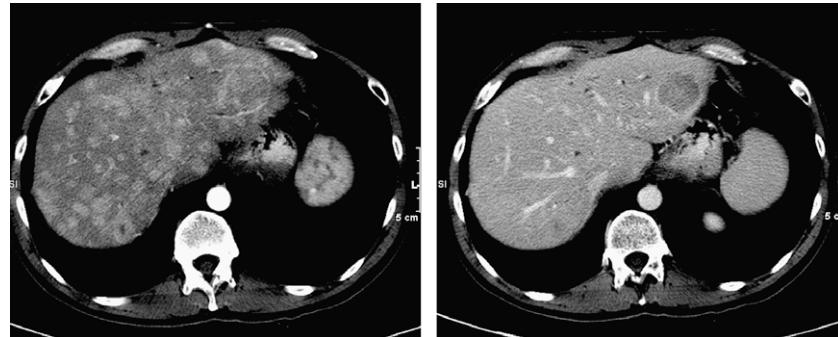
Difference in measurement/visualisation with different phases of IV contrast administration. Hypervascular metastases imaged in the arterial phase (left) and the portal venous phase (right). Note that the number of lesions visible differs greatly between the two phases of contrast administration as does any potential lesion measurement. Consistent CT scan acquisition, including phase of contrast administration, is important for optimal and reproducible tumour
